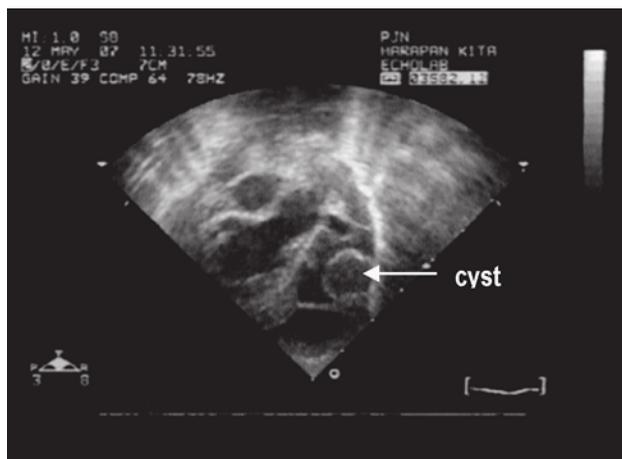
Echocardiography Subxiphoid long axis view showed cyst in the pericardial cavity
